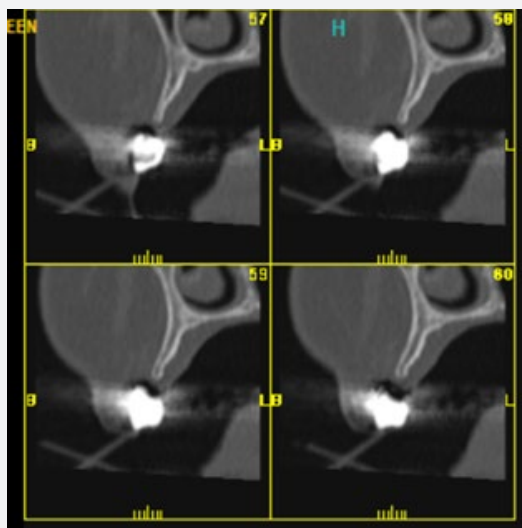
Cross section of the Cone Beam CT image of the maxilla.
